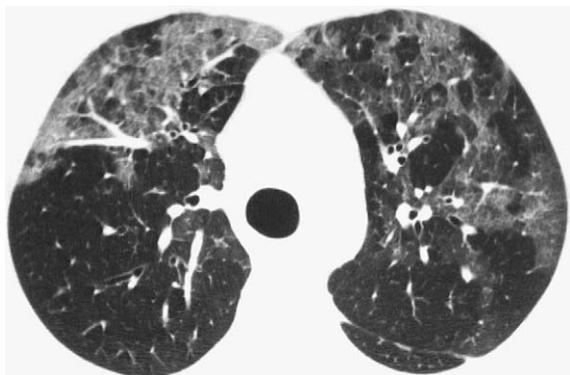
A 46-year-old man with talcosis due to intravenous drug abuse. High-resolution CT image demonstrates patchy bilateral ground-glass opacities.
